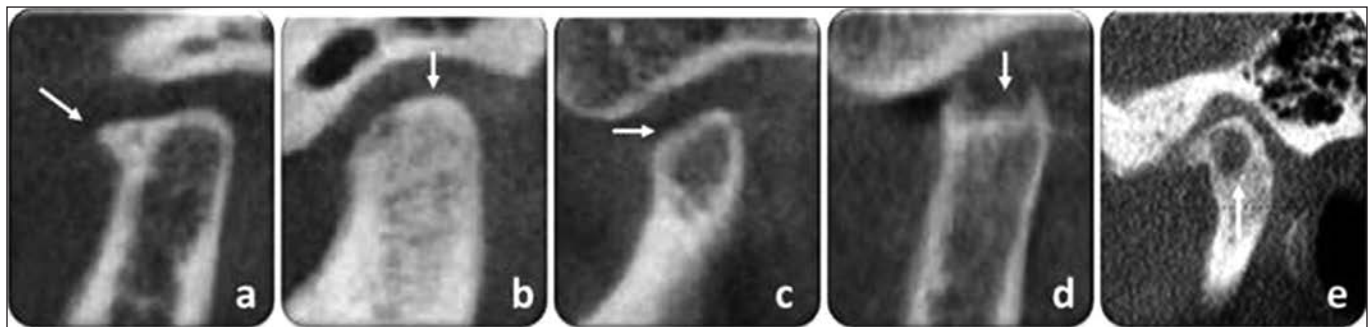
Cone beam computed tomography of different temporomandibular joints analyzed in parasagittal sections (a) osteophyte in the condyle; (b) sclerosis; (c) planning; (d) erosion; (e) generalized sclerosis in the articular eminence and subchondral pseudocyst in the condyle
